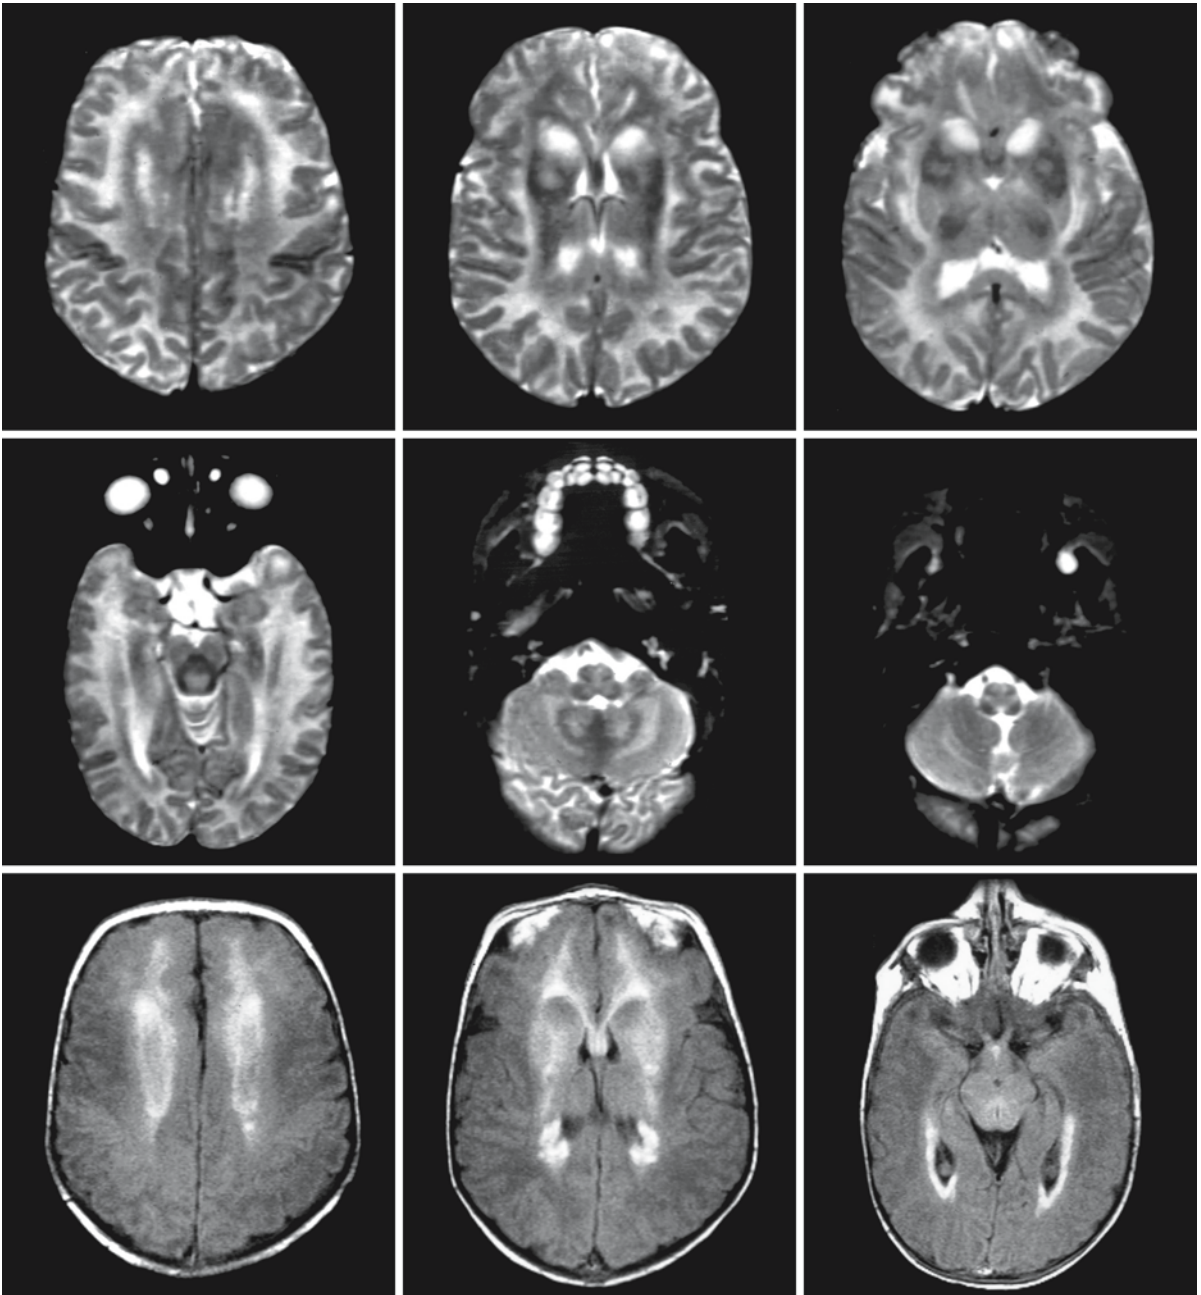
MRI in the same boy as in Fig. 57.1, a few days later. The frontal white matter has at most a slightly abnormal signal intensity on the T_2 -weighted images; its signal intensity is close to normal for unmyelinated white matter. There is a periventricular rim of low signal intensity on the T_2 -weighted images, most prominent in the frontal region. The head of the caudate nucleus is highly swollen and abnormal in signal. The
